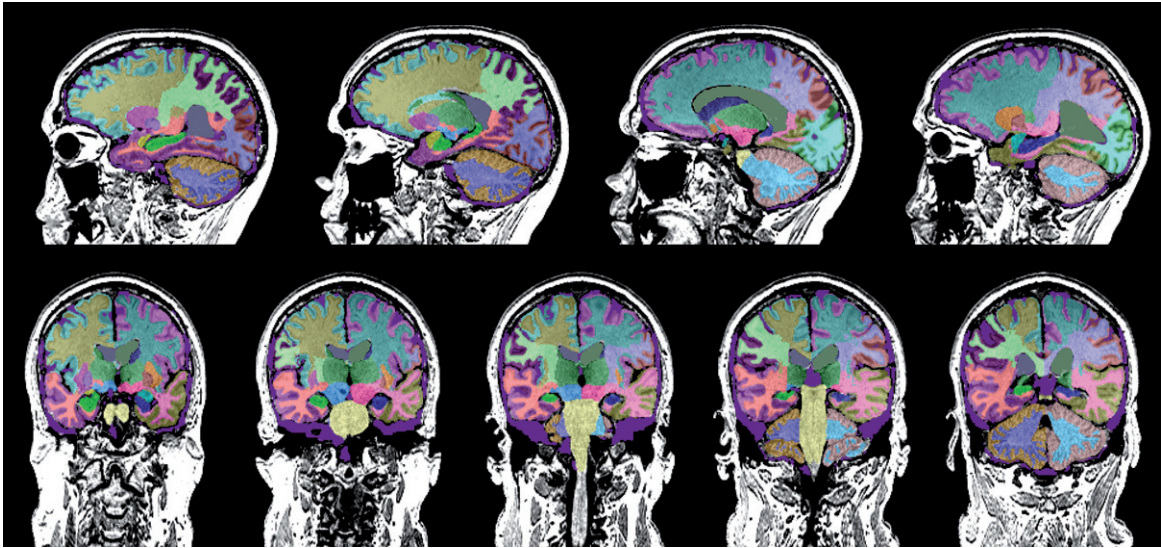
Sagittal and coronal MRI images segmented by Neuroreader for one of the subjects in this study are displayed. Different colors correspond to different regions on different sides of the brain.
